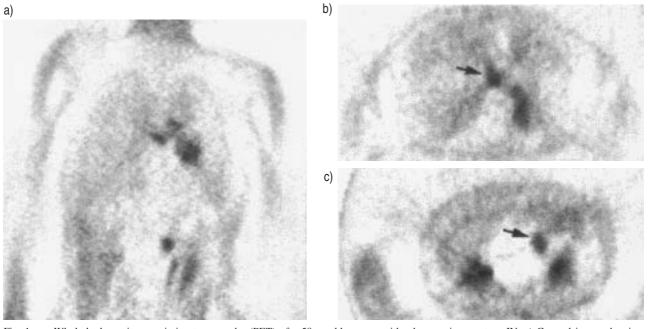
Whole-body positron emission tomography (PET) of a 58 yr old woman with adenocarcinoma stage IV. a) Coronal image showing the fluorine-18 deoxyglucose ( $^{18}$ FDG) uptake in the primary tumour (left lower lobe), in regional lymph nodes and in a distant site. b) Transverse image in mediastinum showing a N3 disease (arrow). c) Transverse image showing a moderate FDG uptake in the area of the left adrenal gland (arrow). Note the tracer accumulation in the urinary tracts.
